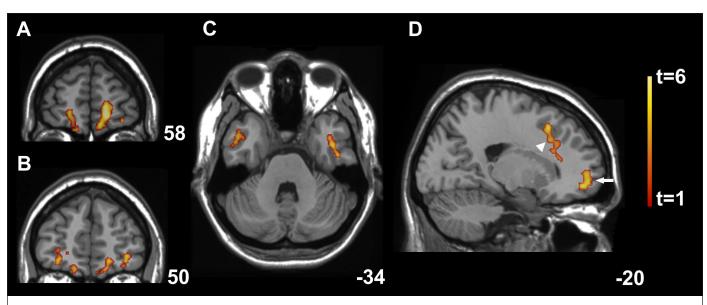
SPM (t) axial maximum intensity projection maps rendered onto a stereotactically normalized MRI scan, showing areas of significant decreases of FA values (color code, yellow to orange) in a cohort of patients with narcolepsy-cataplexy versus healthy control subjects. The number at the bottom right corner of each MRI scan corresponds to the y coordinate (A and B), the z coordinate (C) and the x coordinate (D) in MNI space. Right and left frontal superior orbital gyrus (A), left and right frontal superior and middle orbital gyrus (B), left and right inferior temporal gyrus (C), frontal white matter tracts adjacent to the anterior cingulate (D, arrowhead), and right frontal superior orbital gyrus (D, arrow) are identified.
